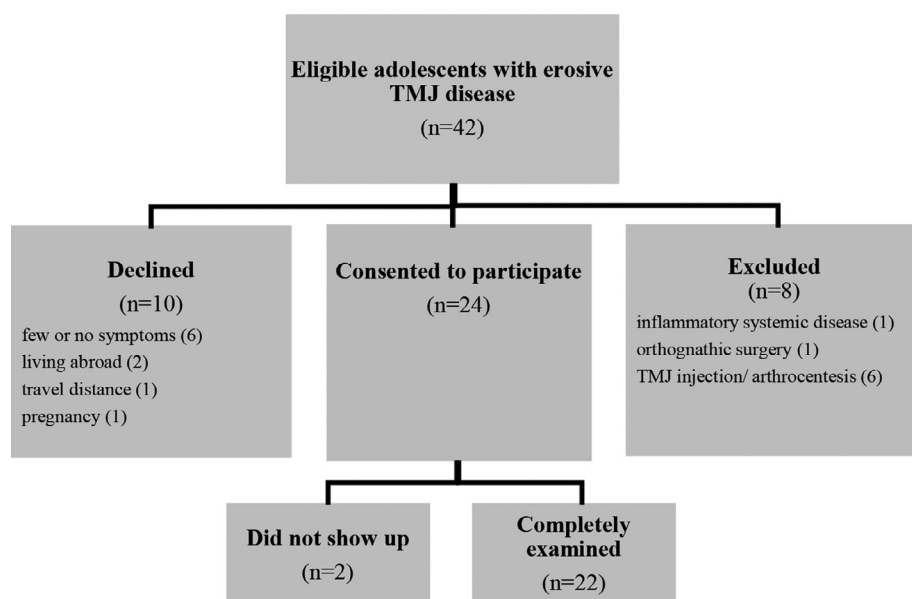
Flow-chart showing inclusion and detailing the reason for decline or exclusion in a CBCT follow-up of symptomatic adolescents with erosive TMJ findings. CBCT, cone beam CT; TMJ, temporomandibular joint
